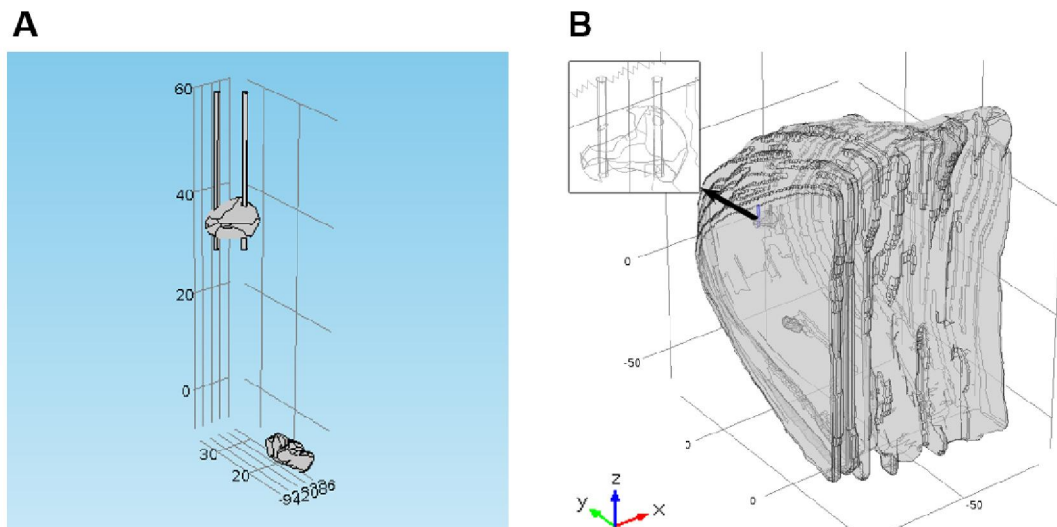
Realistic computational model of two deep-seated breast carcinomas based on MRI imaging. (A) breast carcinomas and two cylindrical conductive
